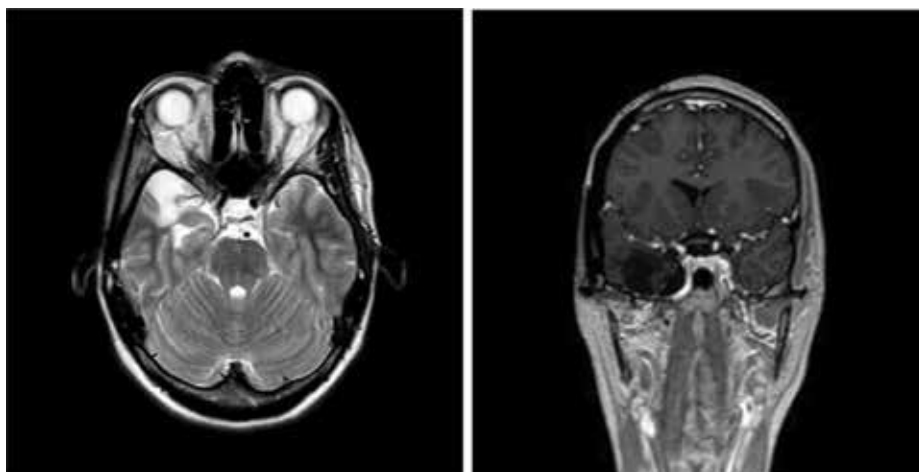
From the left to the right, postoperative T2-weighted image (axial) and T1 coronal with gadolinium after 5 years showing gross total resection without recurrence of the tumor.
